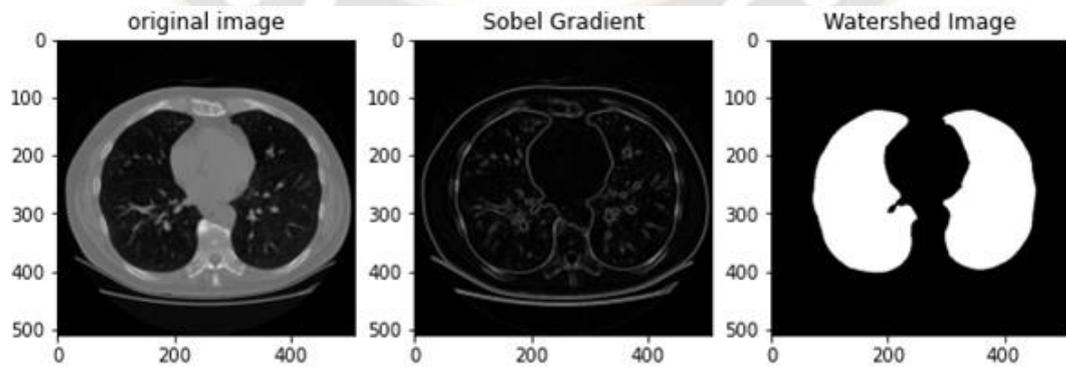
Effect of Water shed markers in CT scan image
